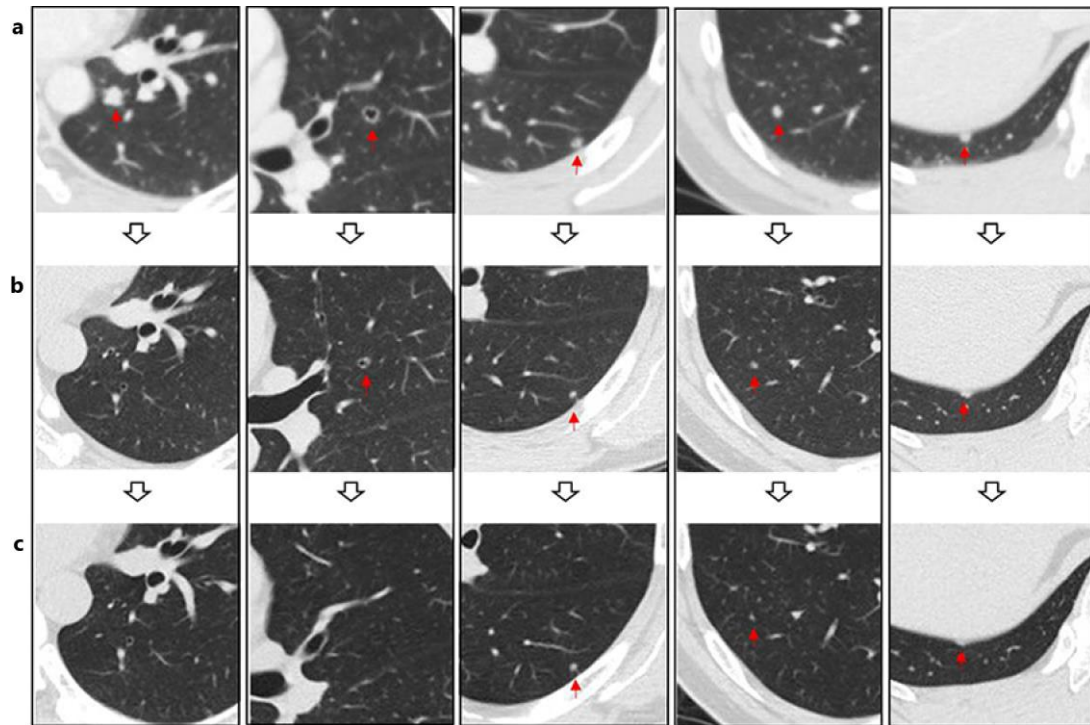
CT revealed multiple nodules, some accompanied by cavitation, in both lung fields (a). CT examination approximately 2.5 months after the start of pazopanib treatment showed a clear reduction in the size of the pulmonary metastases (b). 30 months after the start of pazopanib treatment, most of the metastases have disappeared and shrunken (c).
